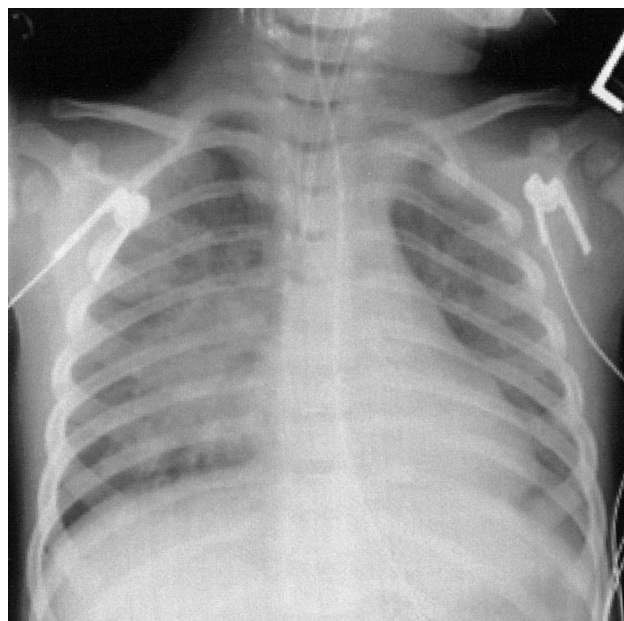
Radiograph after first endotracheal tube change.
